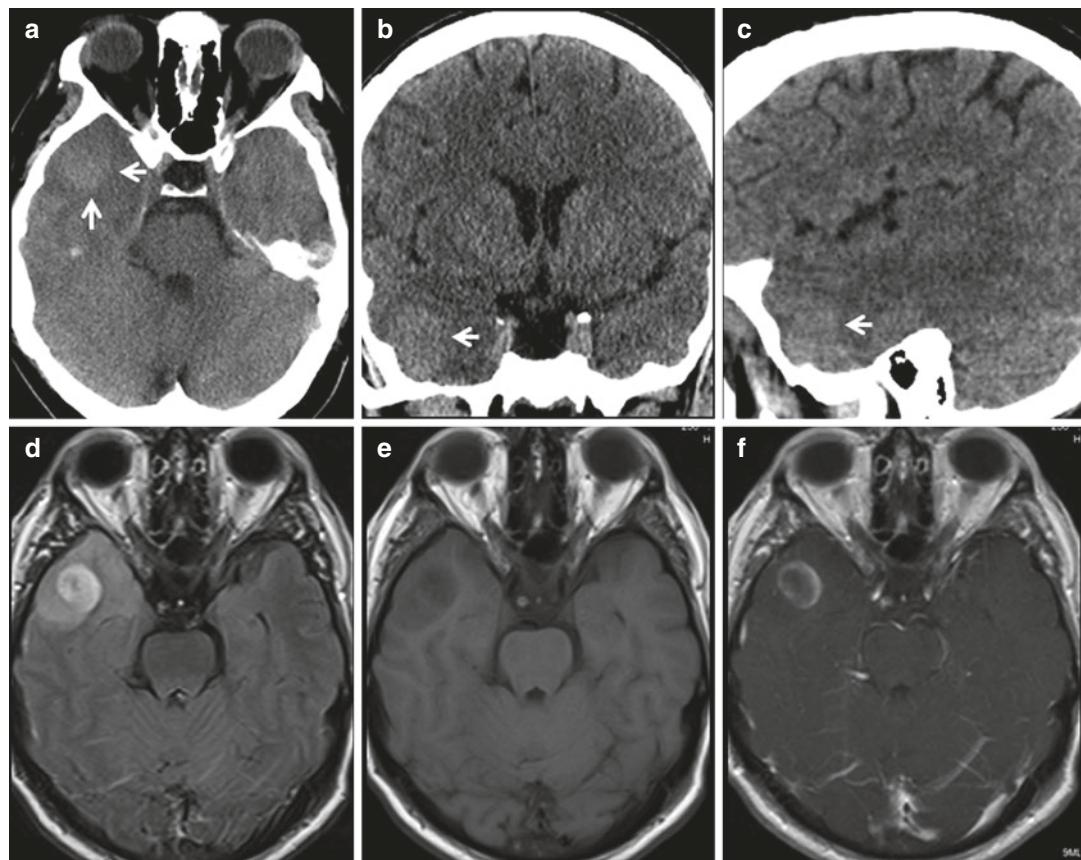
Right temporal lobe glioblastoma in a patient with head trauma. Axial, coronal, and sagittal images of a non-contrast head CT (a–c) show a focal right temporal lobe parenchymal hyperdensity (arrows), interpreted as a hemorrhagic parenchymal contusion, given the history of head trauma from a motor vehicle collision (MVC). Axial
